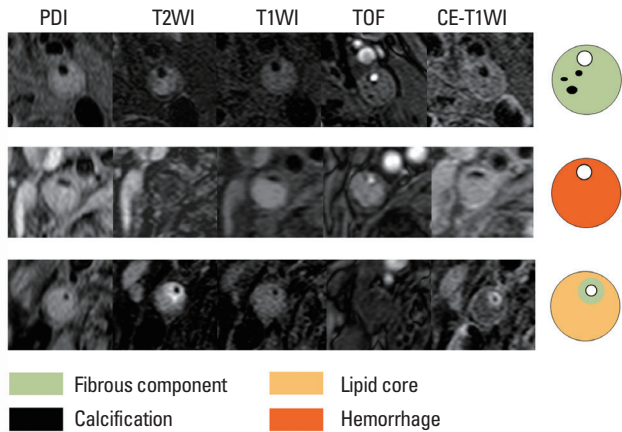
Four main components of atherosclerotic plaques. Axial magnetic resonance images obtained by using five pulse sequences. The fibrous component is isointense on T1WI, T2WI, and PDI with enhancement. Fresh hemorrhage is hyperintense on T1WI and TOF imaging and hypointense on T2WI without enhancement. The lipid core is the area that demonstrates a drop in signal intensity from PDI to T2WI. The calcification demonstrates dark signal intensity on all sequences.
